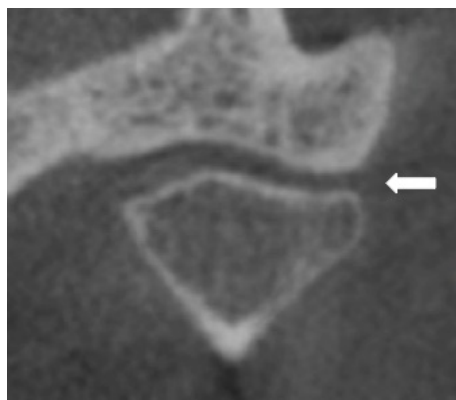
CBCT REVEALING CONDYLAR FLATTENING
